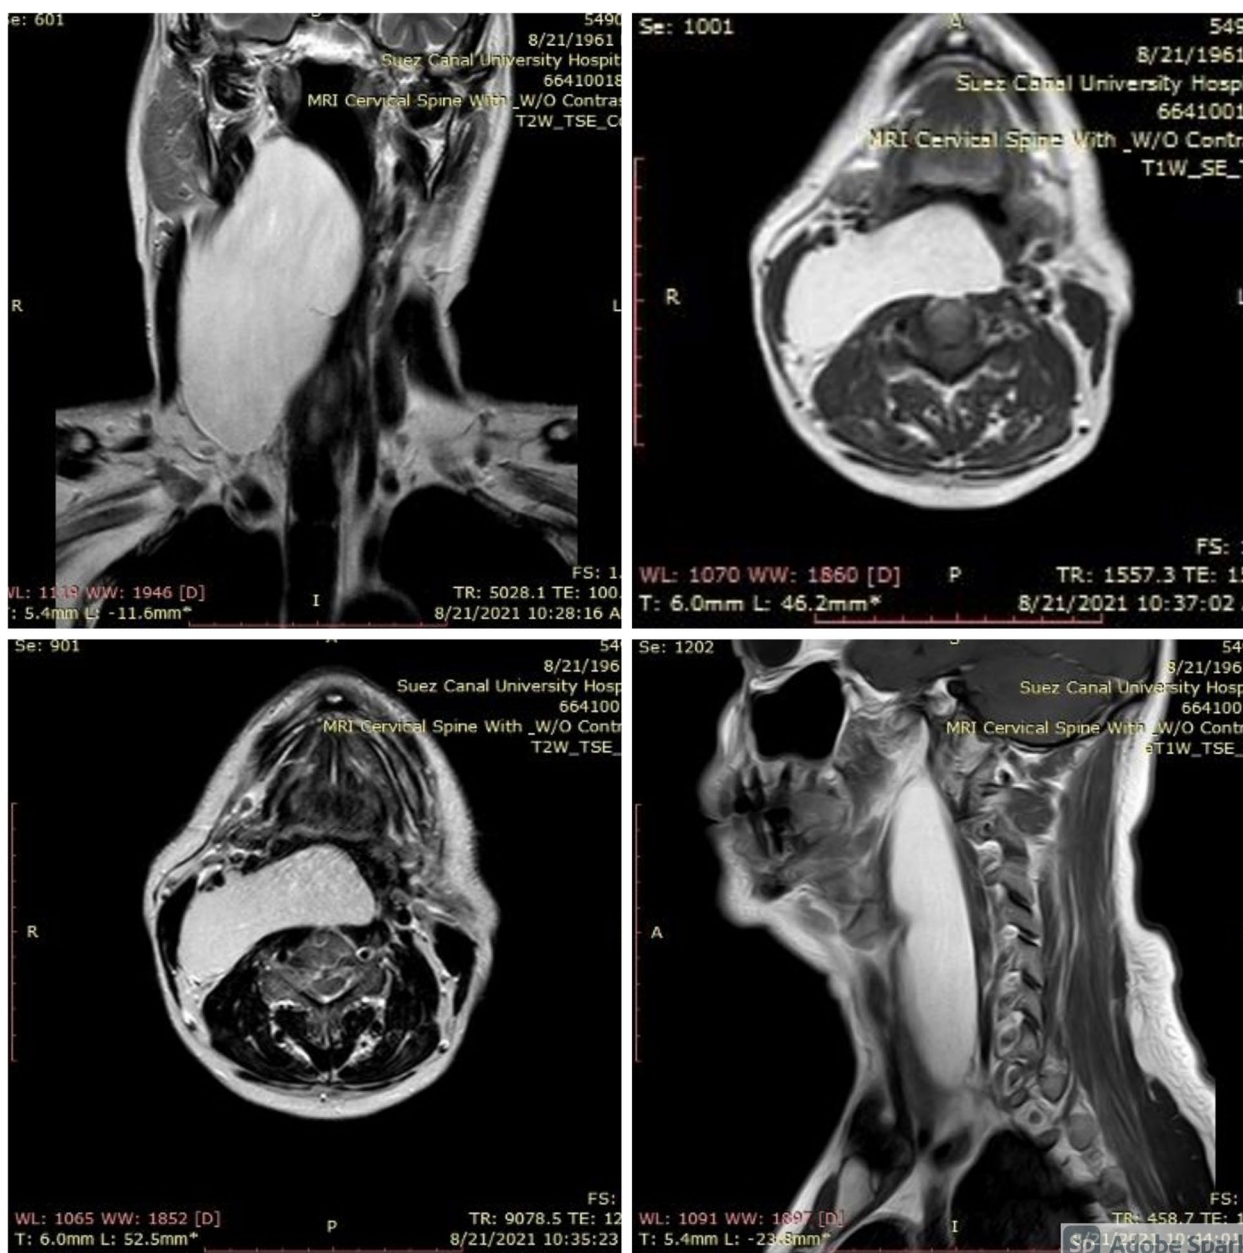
MRI neck showing antero-medial displacement of the oropharyngeal mucosa with encroachment upon the oropharyngeal airway
